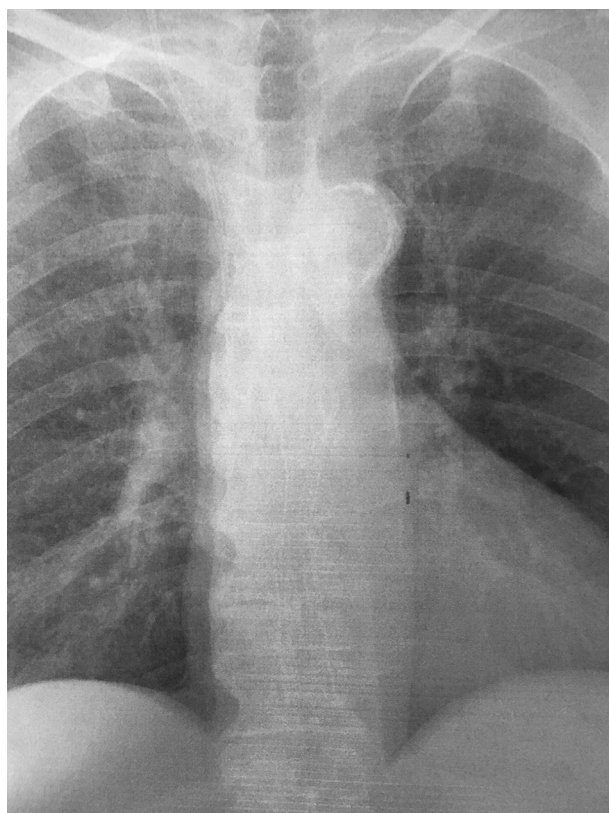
Chest X-ray showing a metal esophageal stent
